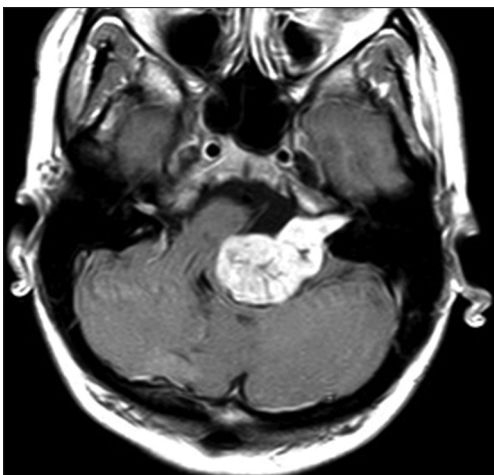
T1-enhanced MRI showing a vestibular schwannoma tumor extension grade 4b (maximal diameter 33 mm) in a 27-year-old woman presenting with hearing loss, facial nerve palsy HB grade III, gait ataxia and mild hemiparesis
